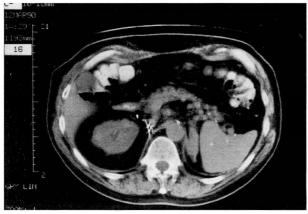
Stable appearance on computed tomography of a metastatic adrenal lesion in a 68-year-old man who had previously undergone a left nephrectomy for renal cell carcinoma. A scan of the abdomen in September 1988 (top) shows a 4×2 -cm lobulated left adrenal mass. A follow-up scan in March 1990 (bottom), obtained with a different field-of-view diameter, shows no significant change in lesion size.
